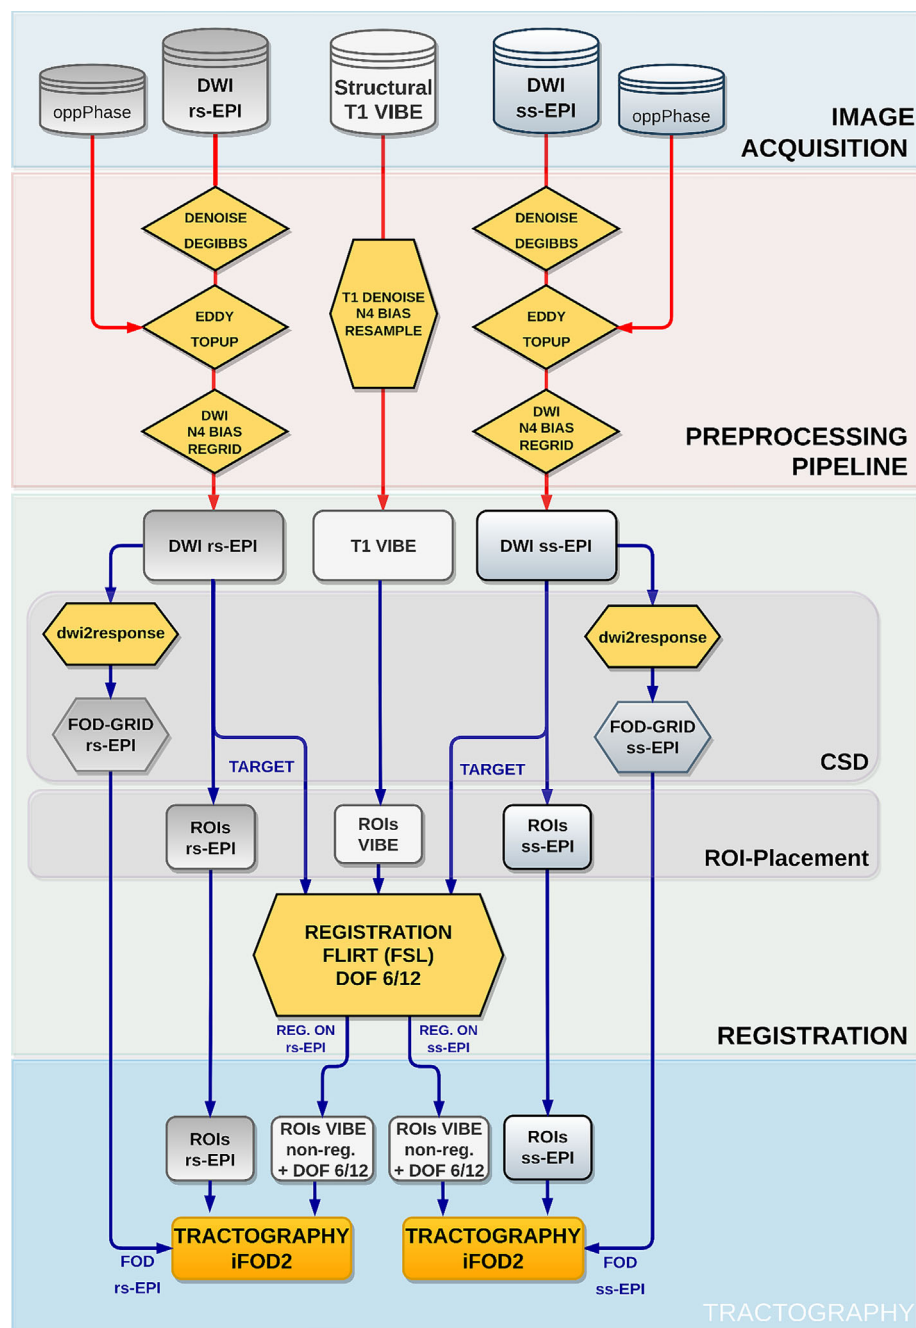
Complete project overview. Raw data in the image acquisition step is represented as stacks and continuously colour-coded in processed panel forms. Executed programmes during preprocessing steps are represented in yellow rhomboids. Prior to the registration of VIBE-drawn regions of interest (ROIs) onto respective diffusion-weighted magnetic resonance imaging (DWI)-variants, fibre orientation distribution (FOD) generation as well as ROI placement by expert readers takes place. Tractography algorithms are shown in orange and use combinations of either rs-/ss-FODs and (un)registered ROIs.
